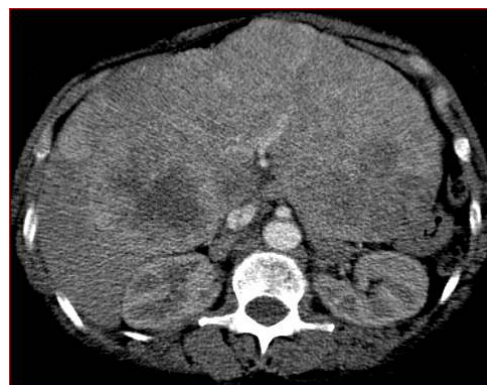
Computed tomography image of the abdomen showing a huge intra-hepatic mass in segments 4a, 4b and 5 with lobulated margins and heterogeneous enhancement post contrast
